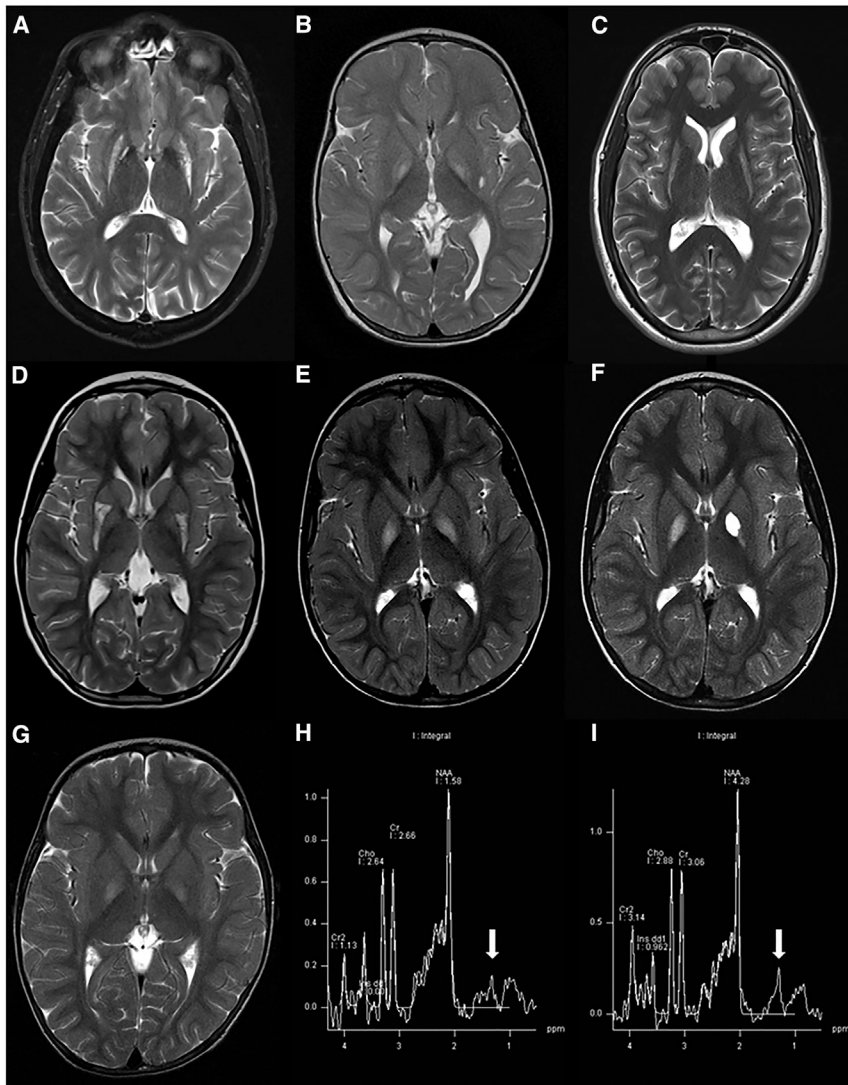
T2 Axial MRI Sections of Affected Individuals Are Suggestive of Basal Ganglia Necrosis
